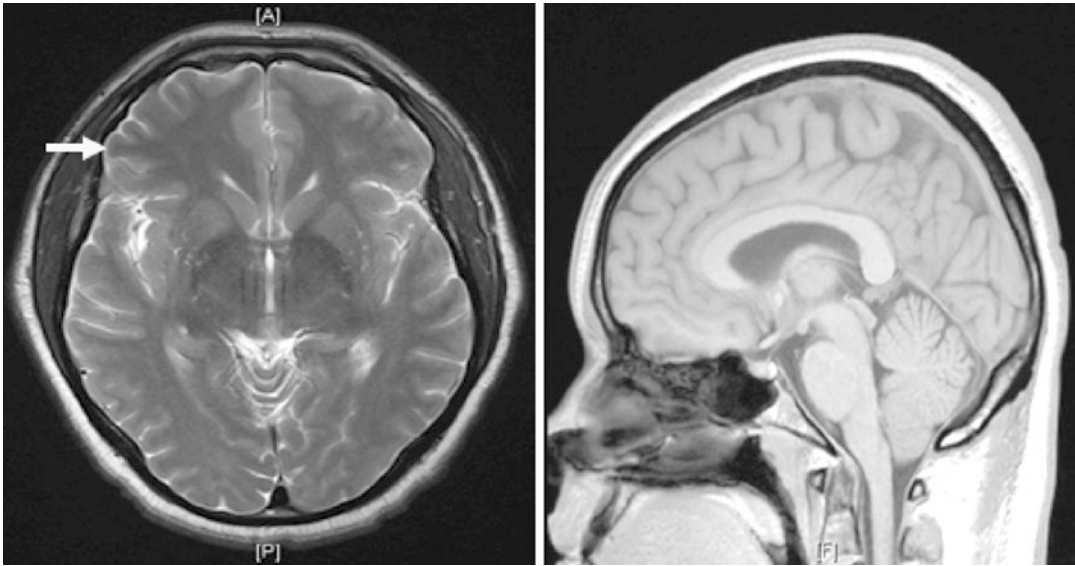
On MRI, small white matter lesions are found in the right frontal area (left) and in the paramedian pons (right). These subtle macroscopic lesions most likely are
